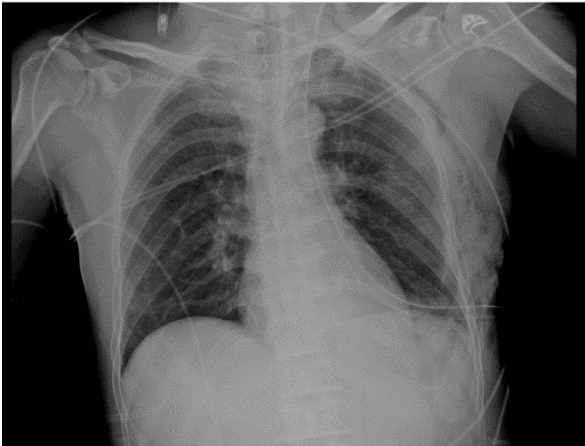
Posteroanterior chest radiography confirms midline positioning of the mediastinal structures with complete restoration of bilateral lungs.
